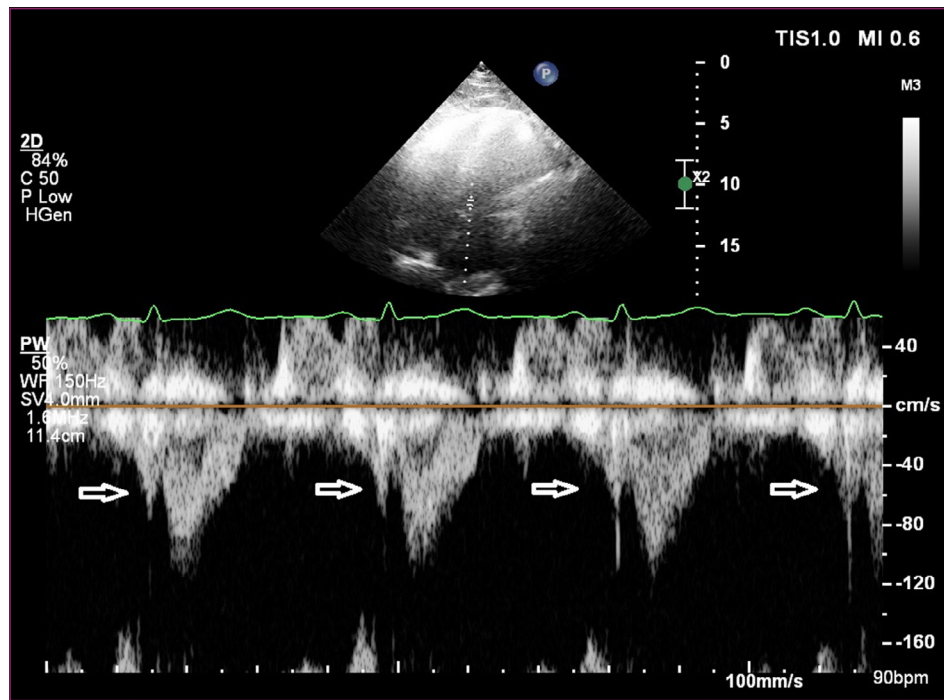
Detection of presystolic waves by echocardiography.
